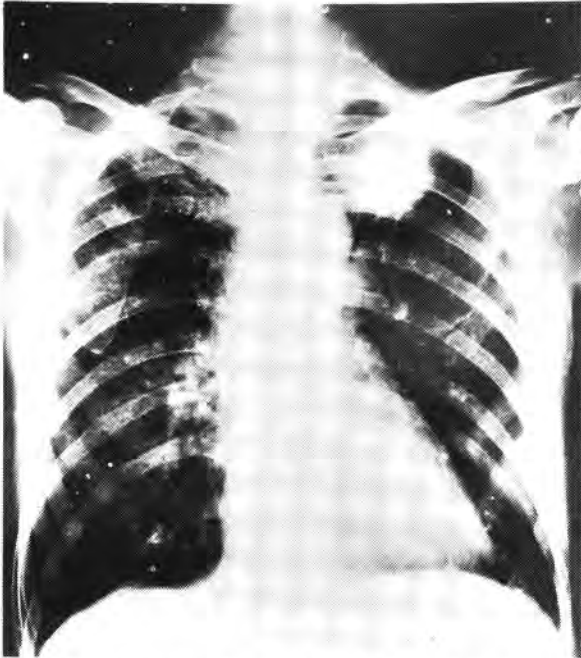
Posteroanterior chest radiograph of a cachetic 65 year old female who complained of dyspnoea and haemoptysis.
